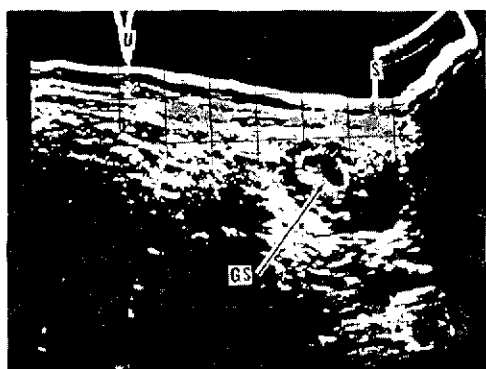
Sonograms showing growth of posteriorly implanted placenta. Top, from left: 8 weeks and 13 weeks. Bottom, from left: 32 weeks and 37 weeks. (A, amniotic cavity; see Figure 7 for other abbreviations.)
